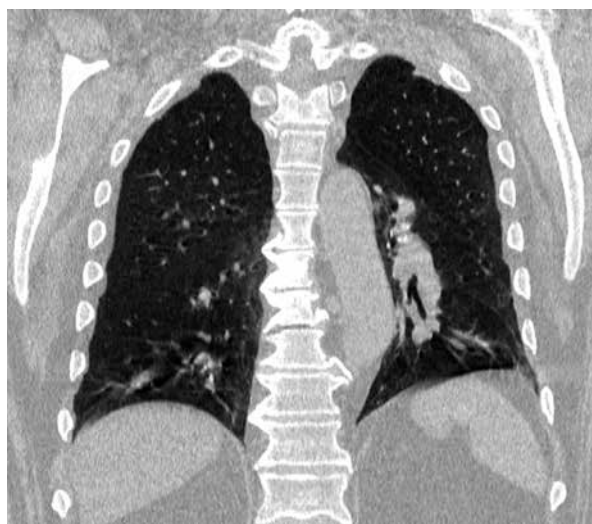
A 79-year-old male patient with neck phlegmon on the left side and COVID-19. Computed tomography of the chest in the frontal plane. Inflammatory changes in the lungs are visible
